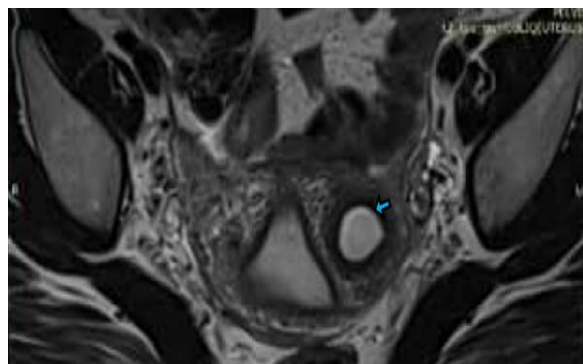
MRI showing normal uterine cavity and the ACUM in T2-weighted image
